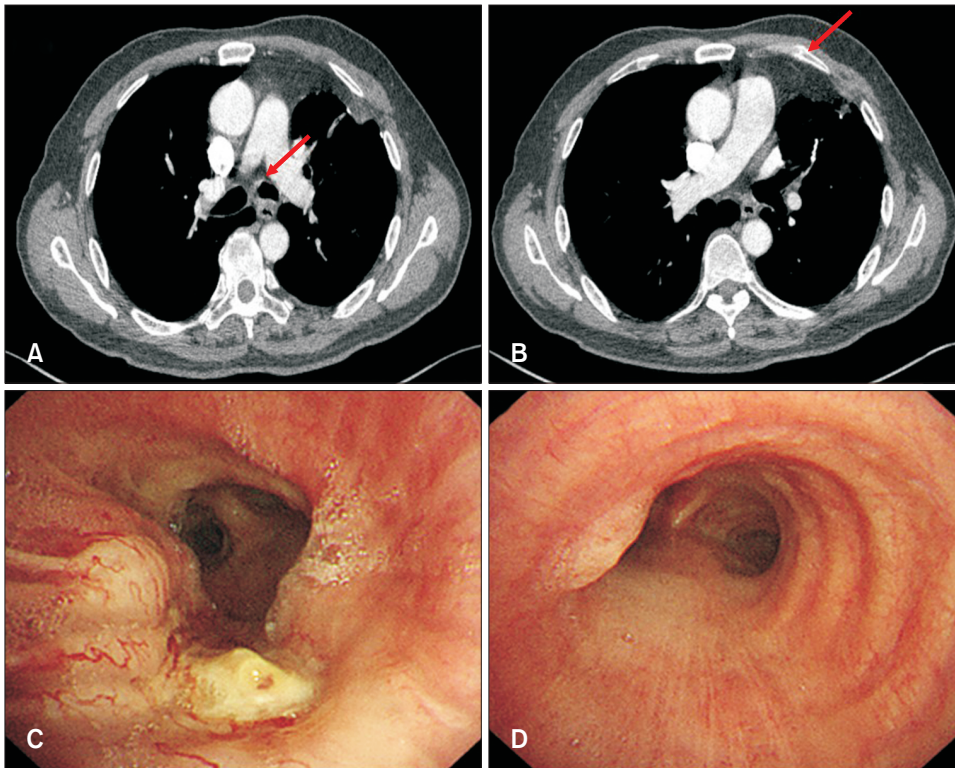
Chest computed tomography showing the proximal portion of the left main bronchus with luminal narrowing (red arrow) (A) and anterior arch pathological fracture of the left third rib (red arrow) (B). Bronchoscopy showing a mucosal lesion, a whitish patch (C), and an elevated polypoid mass in the left main bronchus (D). We received the patient's consent form about publishing all photographic materials.
